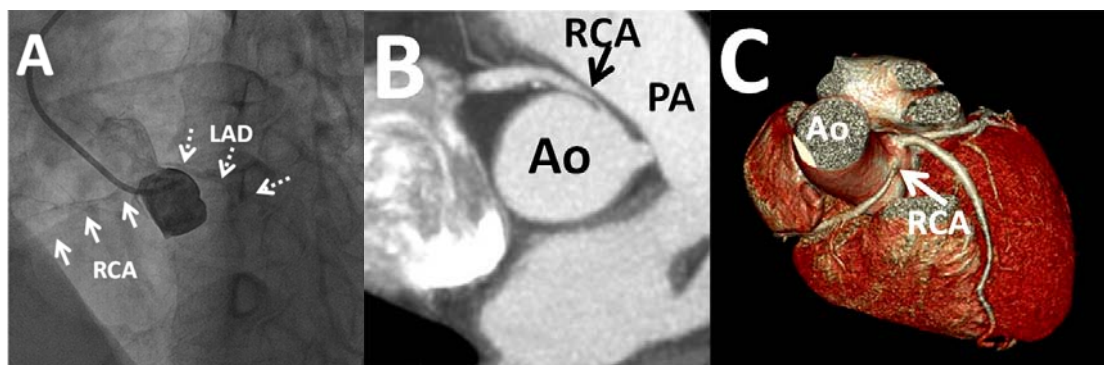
Images obtained in the patient with an anomalous origin of the RCA from the left sinus of Valsalva. Aortic root angiogram (A) shows the anomalous origin of the RCA (arrows), but the exact location of the ostium is not identified. Dual-source computed tomography coronary angiography with a maximum-intensity projection (B) and three-dimensional volume-rendered (C) images showed the RCA originating from the left sinus of Valsalva with the slit-like ostium (arrows) of the RCA is evident where the artery passes between the aortic root and the main pulmonary artery (RCA = right coronary artery, Ao = aorta, PA = pulmonary artery, LAD = left anterior descending artery).
